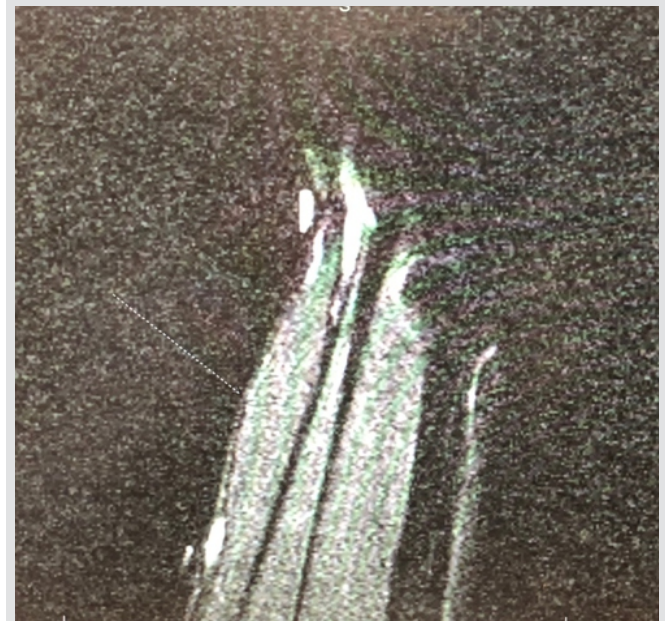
Demonstrated on ultrasound imaging 1 month before the initial follow-up to presenting surgeon/ultrasound of the left anterior wrist area.
